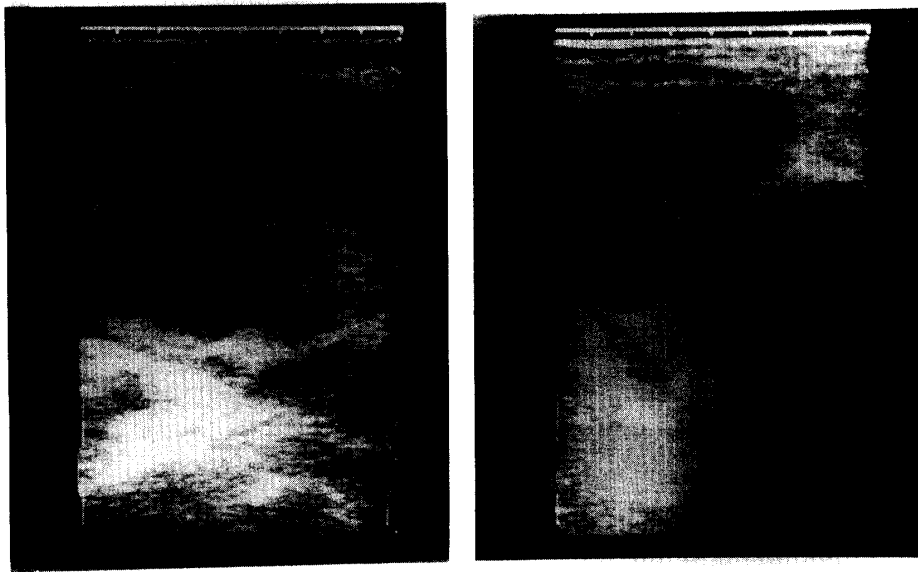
Ultrasonograms of encephalocele. The cerebral falx and midbrain were evident in the cystic mass.
